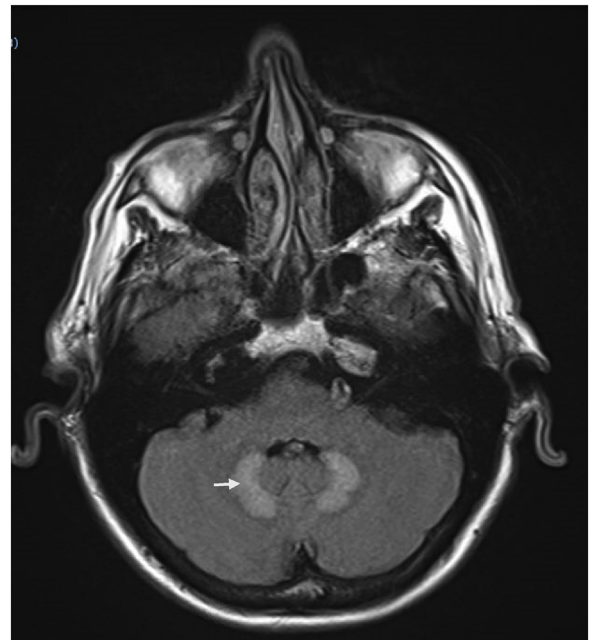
T2/FLAIR hyperintensity in the dentate nuclei bilaterally associated with metronidazole toxicity.
